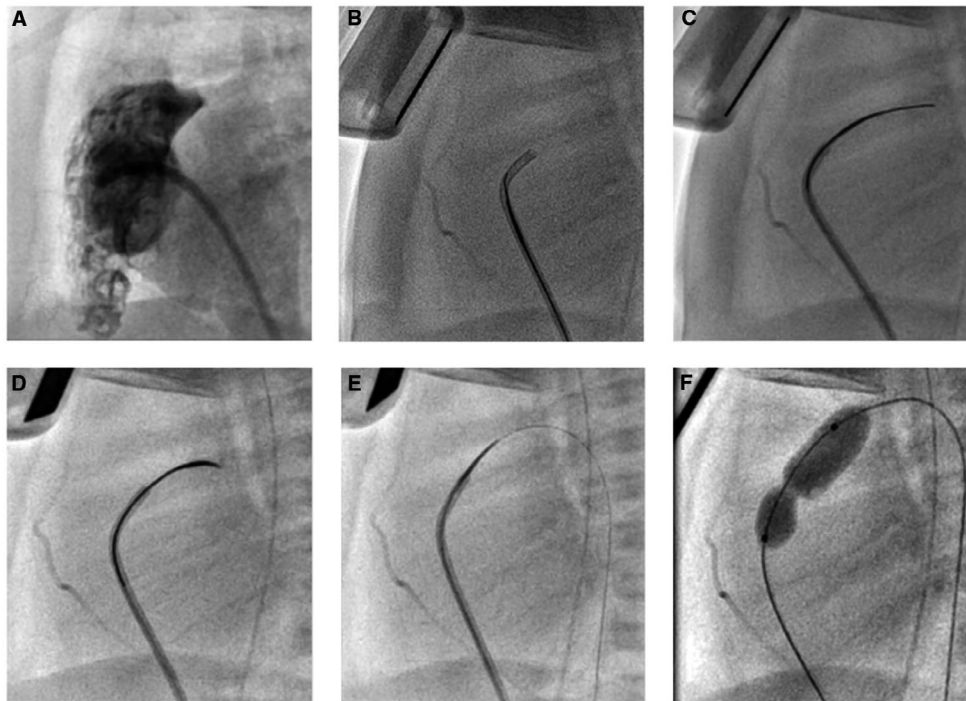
Fluoroscopic acquisitions of the main steps of the perforation procedure. A: Right ventricle angiogram in lateral projection assessing RV volume and pulmonary annulus size. B: Correct positioning of a 5F Judkins right (JR) catheter just below the center of the atretic valve under transthoracic echocardiography and fluoroscopic control. C: Perforation of the pulmonary valve pushing both the CTO guidewire and the microcatheter over the JR. D: Positioning of the microcatheter in the main pulmonary artery. E: Exchange of the CTO guidewire for a flexible wire over the microcatheter, which is positioned in the descending aorta through the ductus arteriosus. F: final dilatation of the valve with 8 mm TYSHAK balloon
